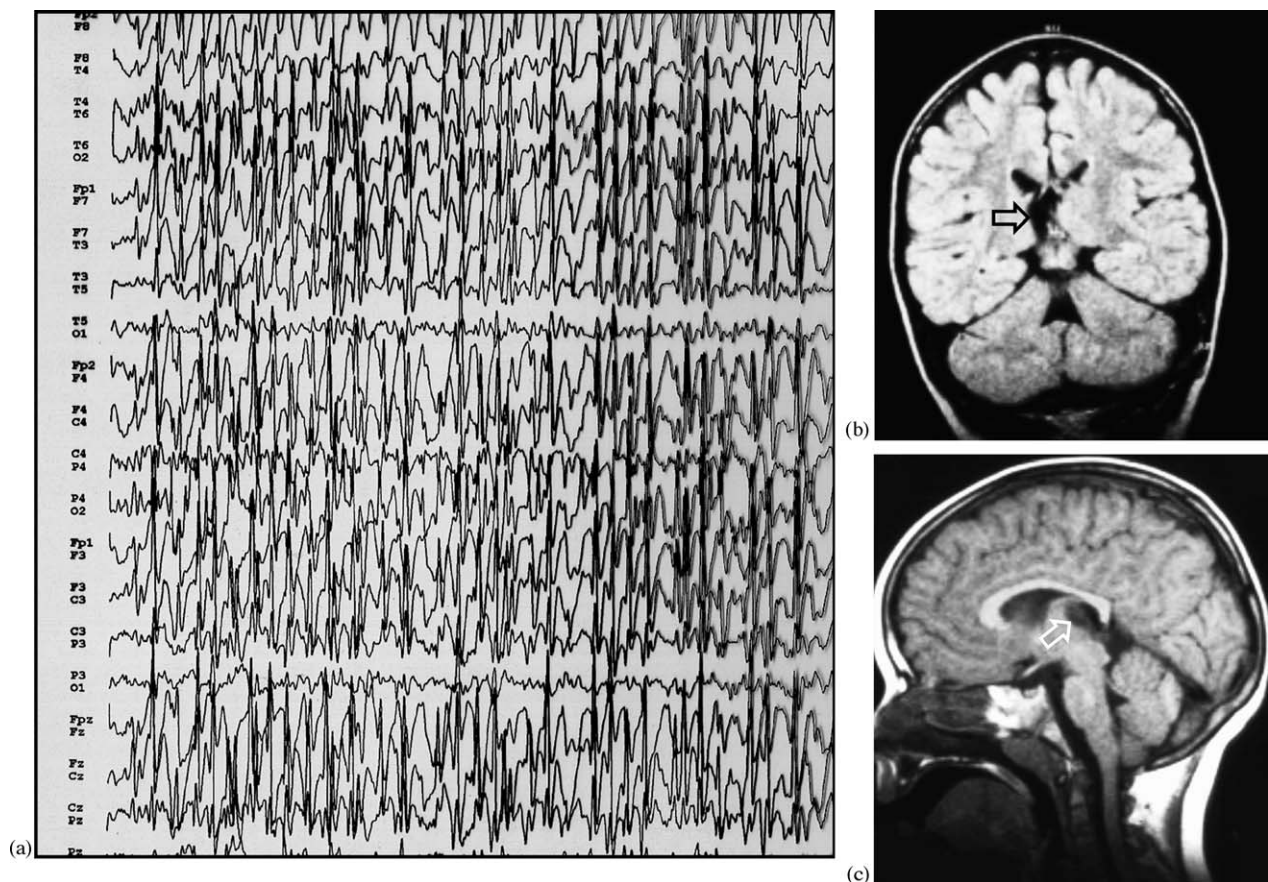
Patient 1: (a) EEG: ESES; (b) coronal FLAIR MRI; (c) sagittal T1 weighted MRI: perinatal lesion in the right thalamus (arrows) in the posterior-medial-inferior region.
